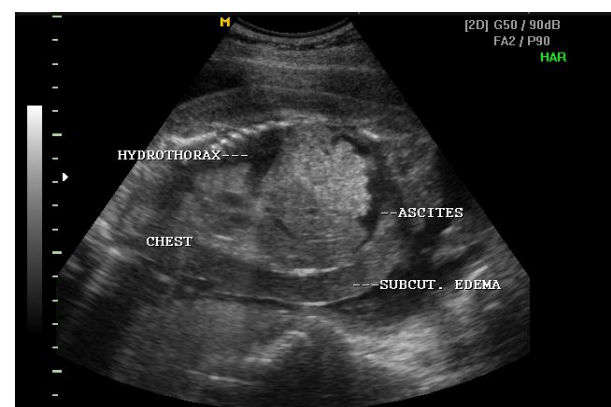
Ultrasound showed hydrothorax, skin edema and ascites
